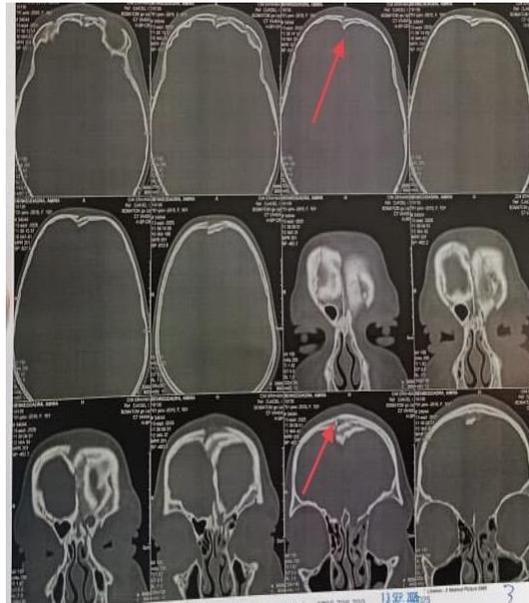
The Preoperative Brain CT Scan Revealed A Fronto-Ethmoidal Fracture.
